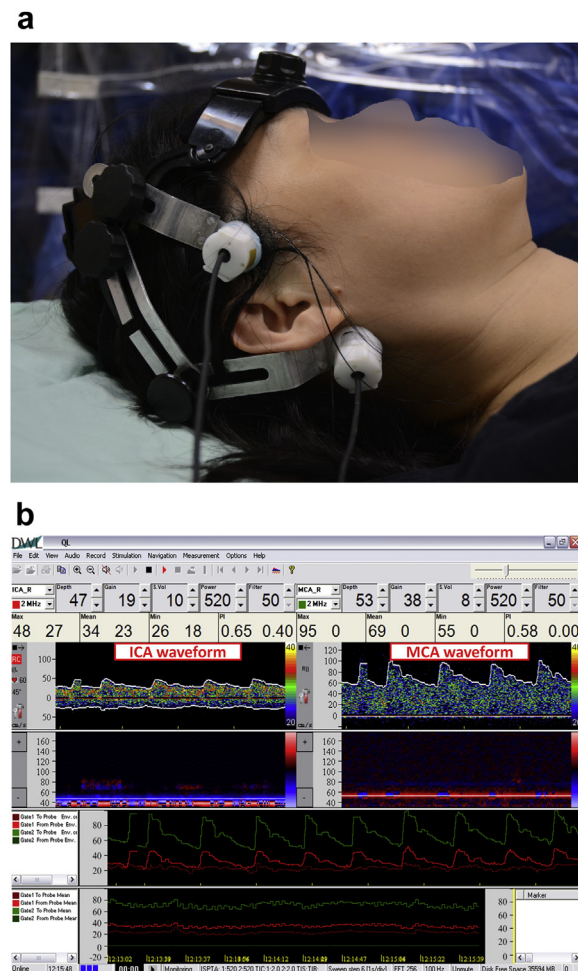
(a) Probe position for the extracranial ICA and MCA. (b) Test settings of the Doppler monitor and the blood flow velocity waveforms of the extracranial ICA and MCA. ICA = internal carotid artery; MCA = middle cerebral artery.
